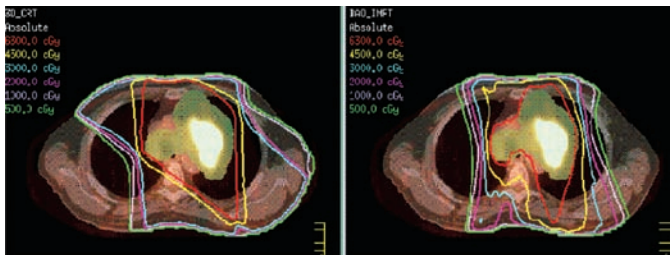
4D-CT scans showing a comparison of dose distributions of an IMRT plan for a patient with NSCLC. Please refer to full legend on page 74.
